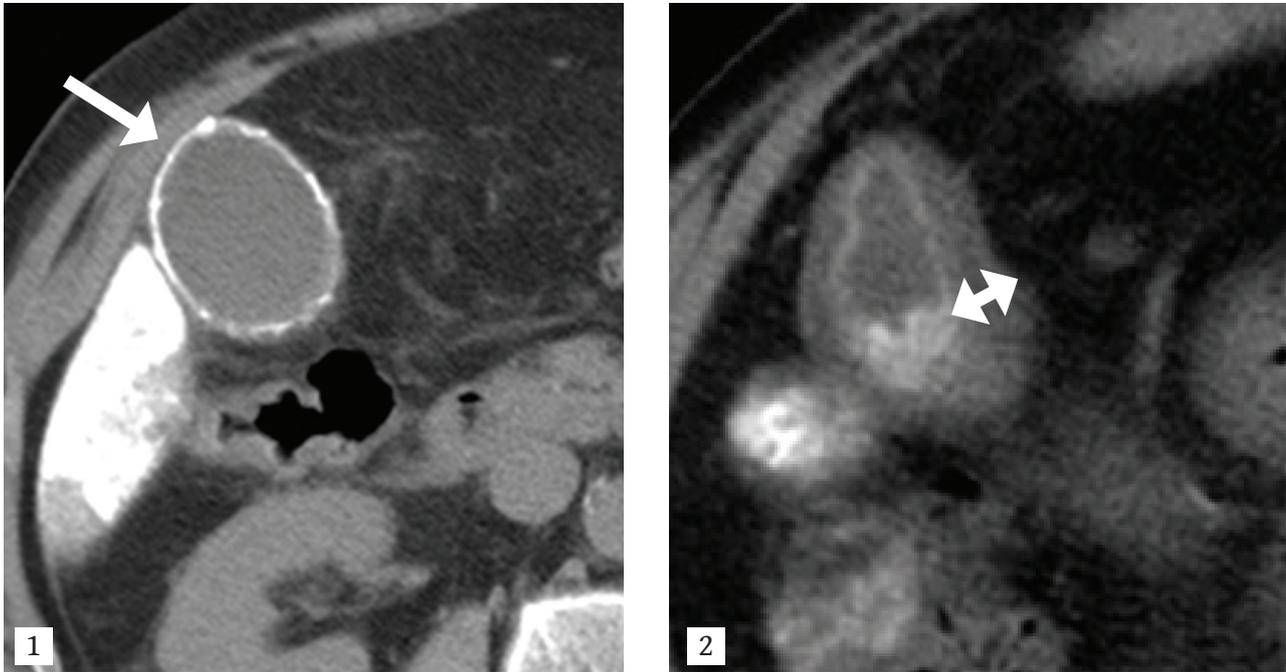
Non-target embolization to the gallbladder. Axial non-contrast CT image obtained without oral or intravenous contrast showed high density material in the mucosa (white arrow) of the gallbladder (1). Care should be taken to exclude porcelain gallbladder by comparing with prior studies. In some cases non-target embolization to the gallbladder is accompanied by the wall edema (double arrow) (2)
